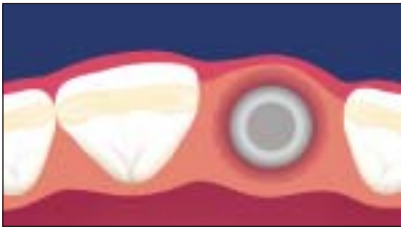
(Right) Following implant restoration, some peri-implant bone resorption is routinely seen on periapical radiographs. This bone "saucer" has a vertical component of about 1.5 to 2.0 mm and a horizontal component of at least 1.0 mm.
